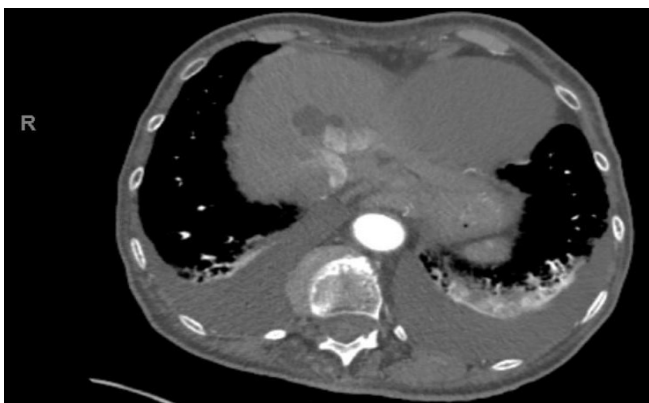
CT(computed tomography) chest showing bilateral pleural effusions
